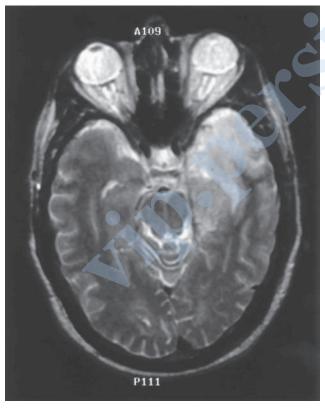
T2-weighted MRI shows classic high signal intensity lesion in left temporal lobe in herpes encephalitis.
